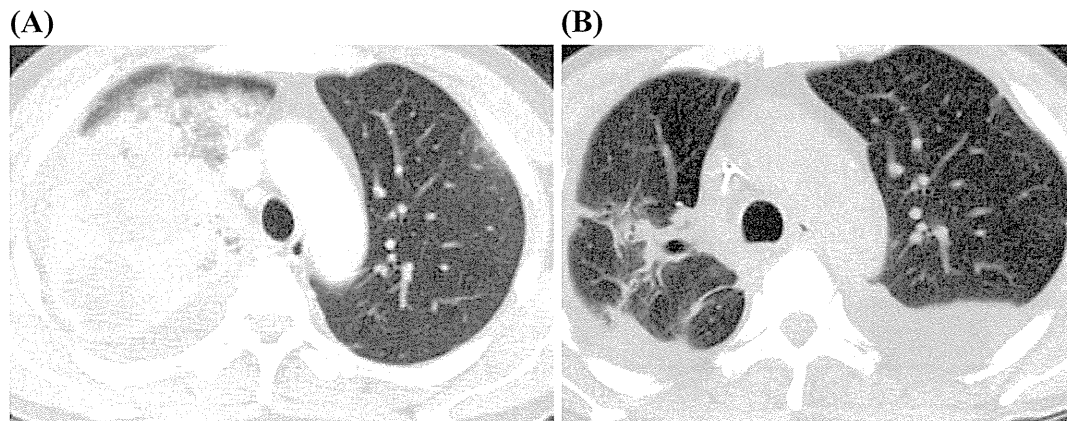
(A) High-resolution chest computed tomography (HRCT) disclosed consolidation and pleural effusion on day 63 after the initiation of induction therapy. (B) HRCT performed on day 37 after allo-HSCT showed an improvement of the lesion in the right lobe.
